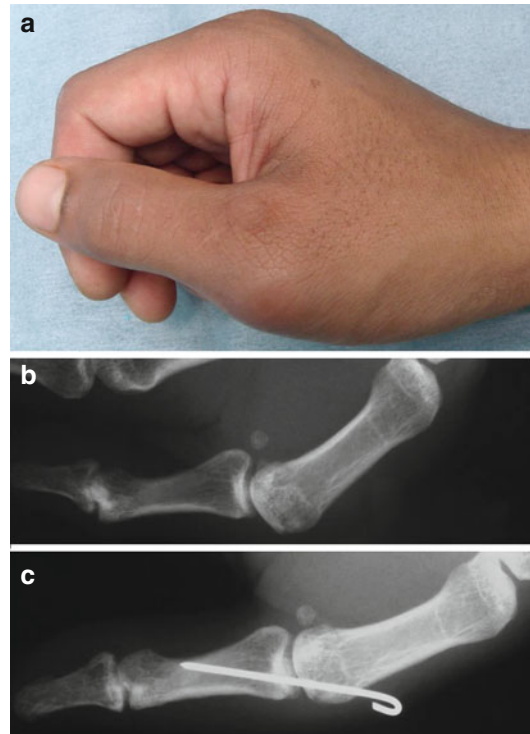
(a) The thumb is in ulnar deviation, pronation and “dropped”. There is a swelling on the radial side of the thumb MCPJ. (b) These features are confirmed on the radiograph below. No fracture is seen. There was a proximal tear of the RCL which was repaired and protected with the Kirschner wire to help reduce the joint (c)
